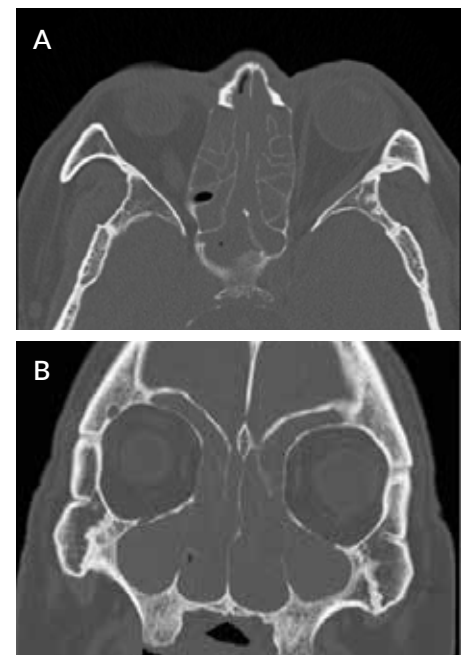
Axial (A) and coronal (B) computed tomography scans of the patient demonstrating a widespread, abnormal soft tissue density, occupying the entire nasal cavity and resulting in osteomeatal destruction.
